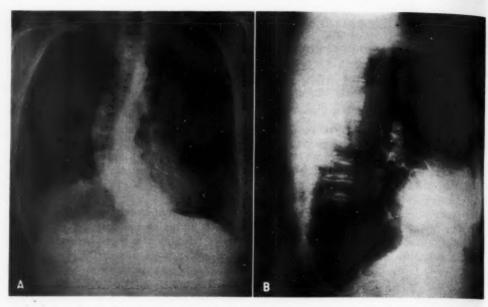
A. Postero-anterior roentgenogram of the chest demonstrating the density obscuring the right cardiophrenic angle. The configuration of the gas pattern within this mass suggests intestinal contents. A moderately severe scoliosis of the thoracic spine is noted.
